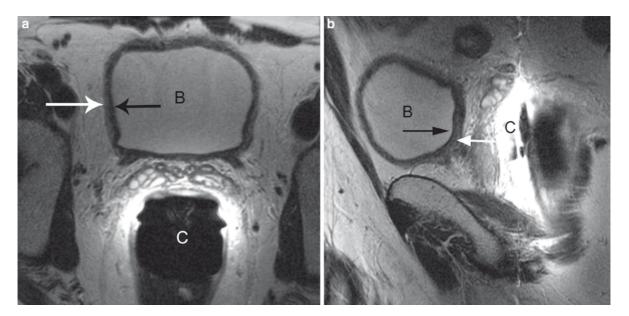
(a–b) Normal bladder wall on (a) axial and (b) sagittal T2-weighted images obtained using an endorectal coil (c). Note the low signal intensity muscle layer (*black arrow*) relative to high signal intensity urine in the bladder-B, and the intermediate signal intensity outer serosal layer (*white arrow*). The mucosal/submucosal layer is not discernable from the muscle layer
